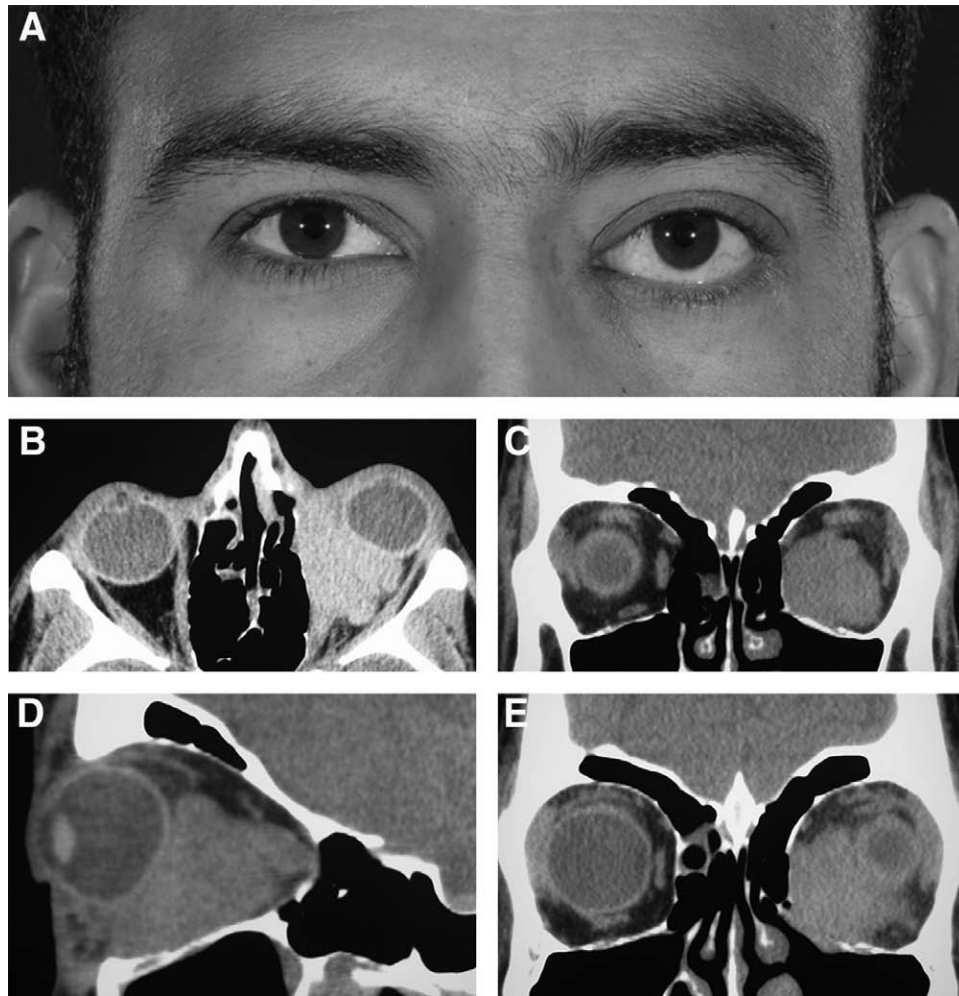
Case 6. Sclerosing orbital, lacrimal system and nasal disease, formerly known as eosinophilic angiocentric fibrosis. A, A 25-year-old man presented in 2008 with 6 months left epiphora and proptosis, with a lacrimal mucocele. There was a hard inferomedial orbital mass. B, C, D, and E, CT scans showed a large dense mass involving the inferomedial orbit compressing and displacing the globe. A biopsy diagnosed eosinophilic angiocentric fibrosis (an image of this can be seen in Part 1 of this review). He then underwent a DCR with repeat biopsy of the orbit and thickened nasal mucosa. There was dense fibrosis with large numbers of IgG4+ plasma cells and a mild increase in serum IgG4. He was commenced on oral steroids and methotrexate with stabilization of disease. Rituximab is being considered if his disease worsens.
